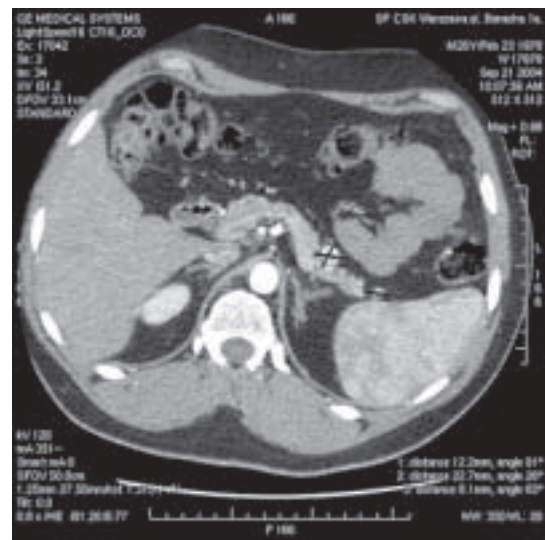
Computed tomography of the abdomen showing further growth of the lesions (year 2004)
